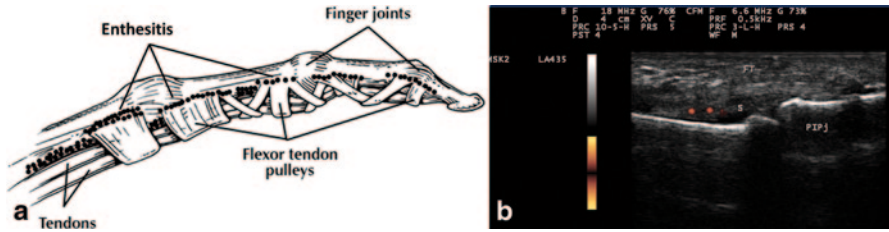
a Picture of a flexor tendon clarifying the role synovio-entheseal complex in the pathogenesis of enthesitis. *Dots* show sites of inflammation—enthesitis. b Grayscale US of a finger showing enhanced vascularity at the synovio-entheseal complex. US ultrasound
